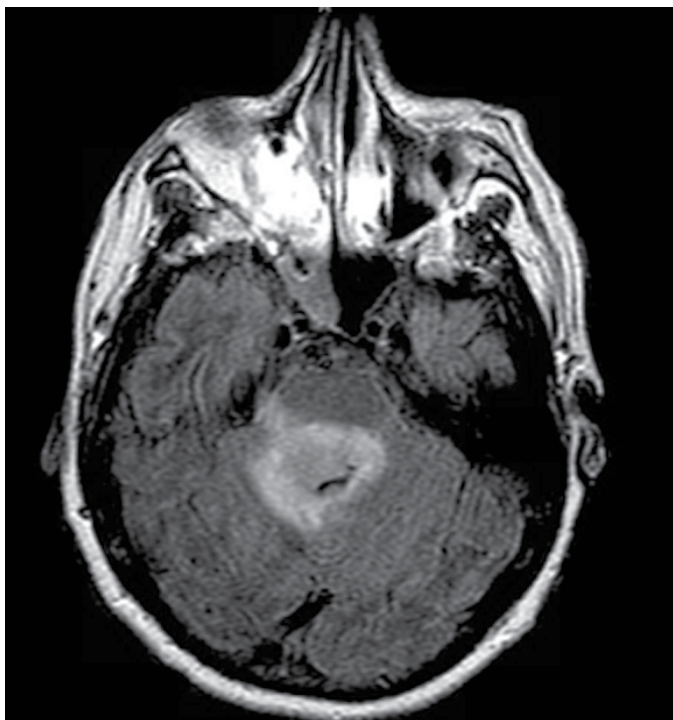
Magnetic resonance imaging of brain. T2/Flair imaging showing hyperintense process on in the brainstem with extension to cerebellum. Additionally, there were lesions present in the right thalamus and periventricular/subependymal areas.
